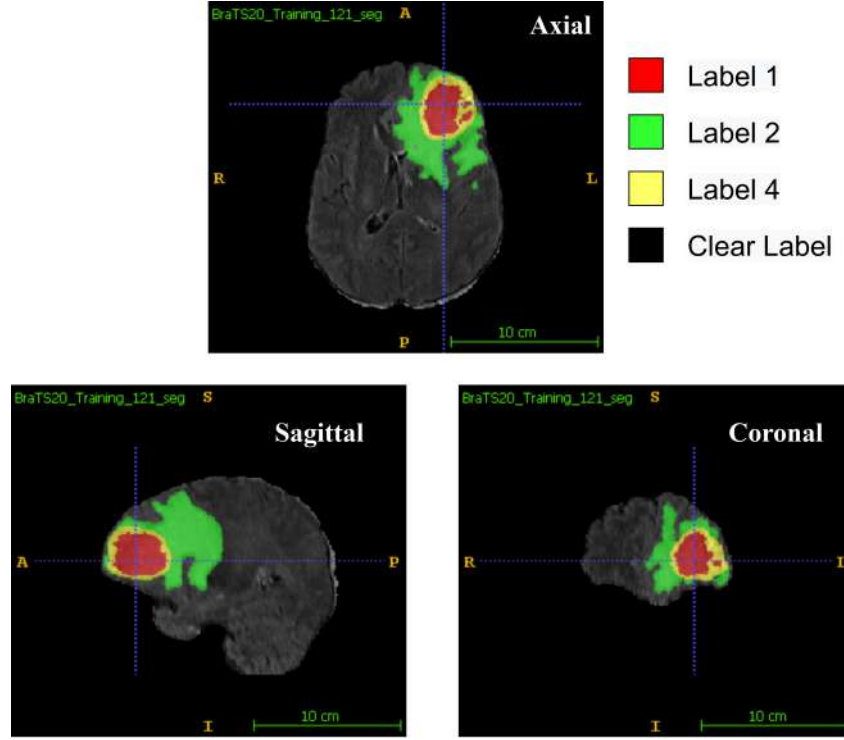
MRI Scans with Segmentation Labels in Multiple Views [1]
